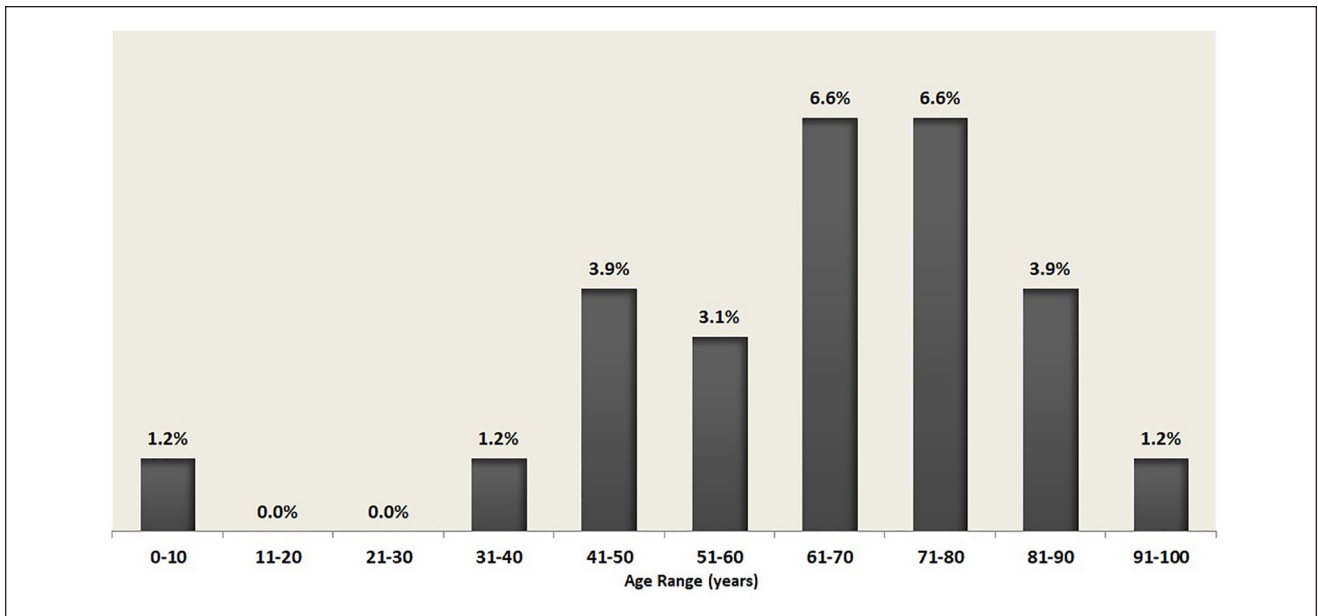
Post-implantation MR imaging needs identified in cochlear implant recipients by age.
